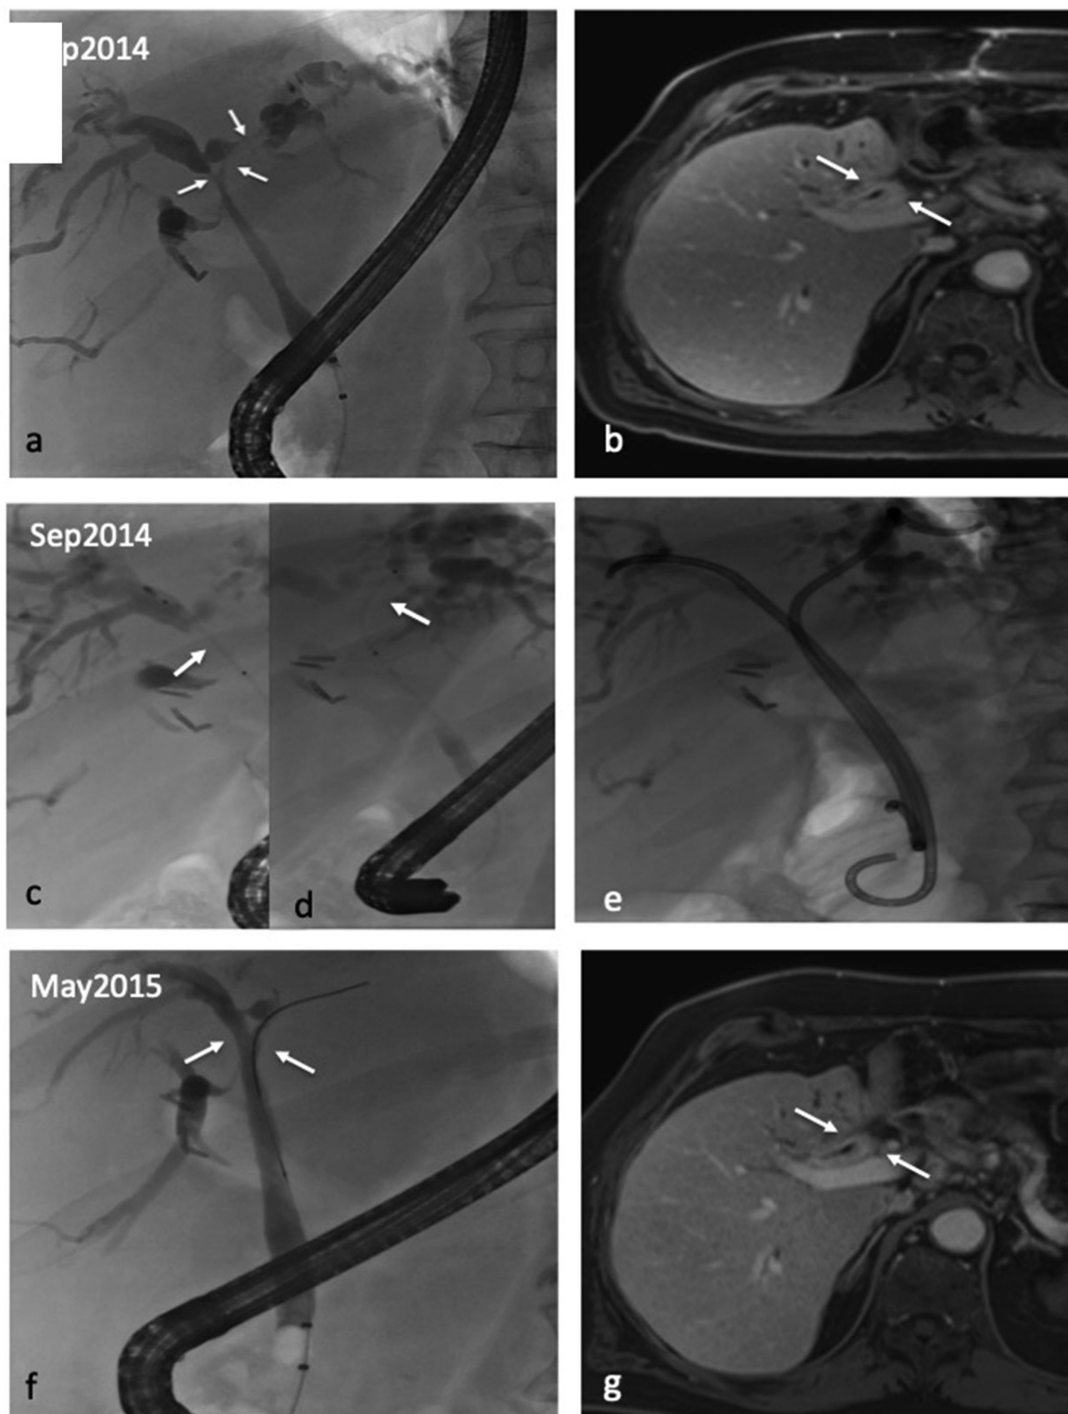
Effect of PCI treatment in a patient with hilar cholangiocarcinoma (cohort 2) (A) Fluoroscopic imaging of the hilar stenosis with dilated intrahepatic bile ducts at study entry; (B) Thickening of the central bile duct wall in corresponding MRI; (C, D) Fluoroscopic imaging of the cylindrical light diffuser in the right (C) and left (D) main hepatic bile ducts. (E) Biliary drainage with plastic stents. (F) Fluoroscopic imaging of the hilar region with only a minimal residual stenosis in the main left bile duct at the end of treatment; (G) unchanged thickening of the central bile duct wall in corresponding MRI.
